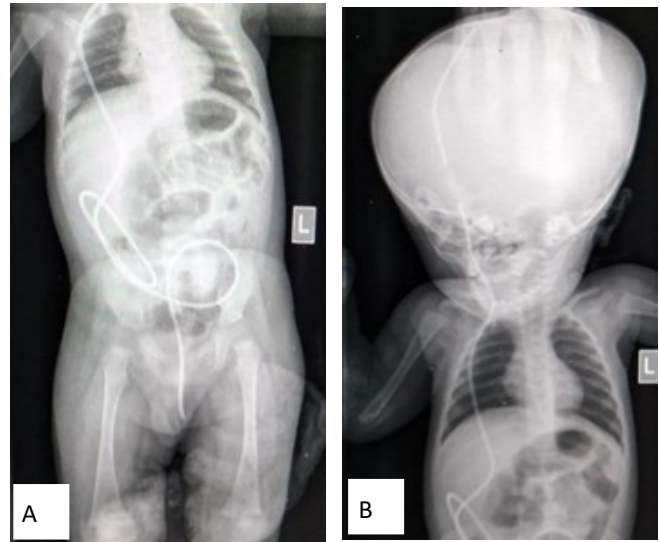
Shunt series X-ray (A, B)
